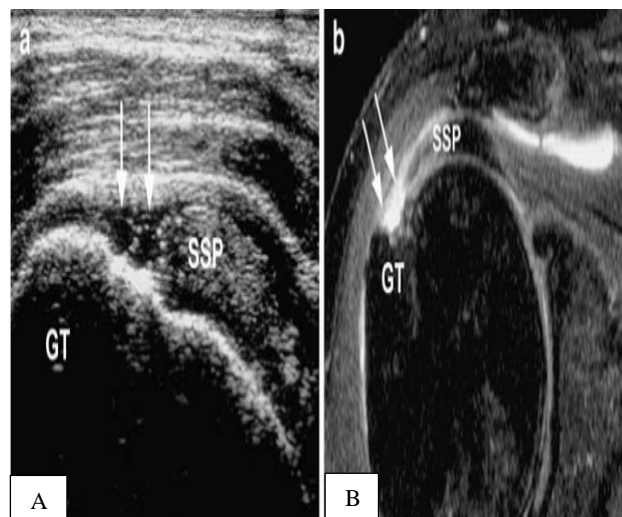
(A and B): Full-thickness rotator cuff tear. Ultrasound appearance of a full-thickness tear (arrows) at the insertion of the supraspinatus tendon (SSP).
